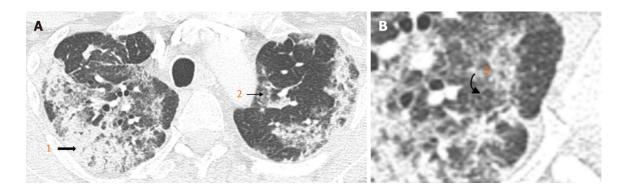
Chest X-Ray. A: Typical appearances of COVID-19 infection: Bilateral peripheral consolidation (1. block arrow), multifocal groundglass opacities (2. straight arrow); B: Some areas of smooth intralobular septal thickening (3. curved arrow).
